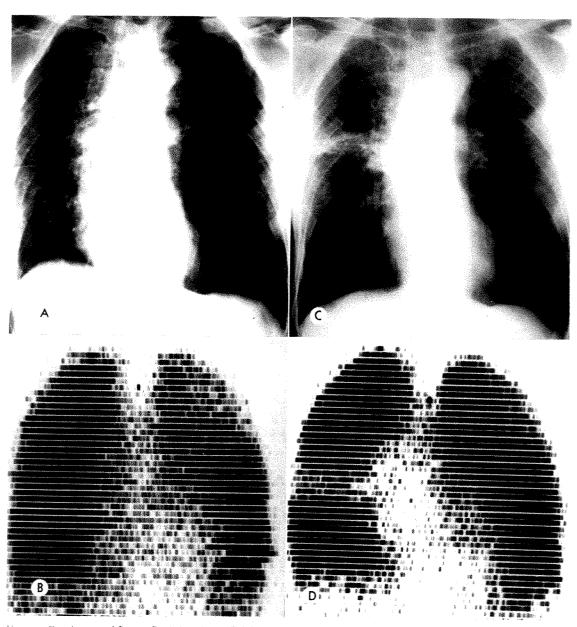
Carcinoma of Lung, Peripheral. (A) Initial roentgenogram and (B) lung scan prior to treatment and 1 month after resection of a 1 cm. bronchogenic carcinoma from the right mid-lung. Despite emphysema, pulmonary perfusion is normal except in the upper third of the left lung. (C) Follow-up roentgenogram and (D) scan were obtained 8 months after delivery of 5,000 r tumor dose to the tumor bed in 43 days using supervoltage equipment. Fibrosis and ischemia in the irradiated region are discrete, localized and commensurate. Patient AW, a 69 year old male.
